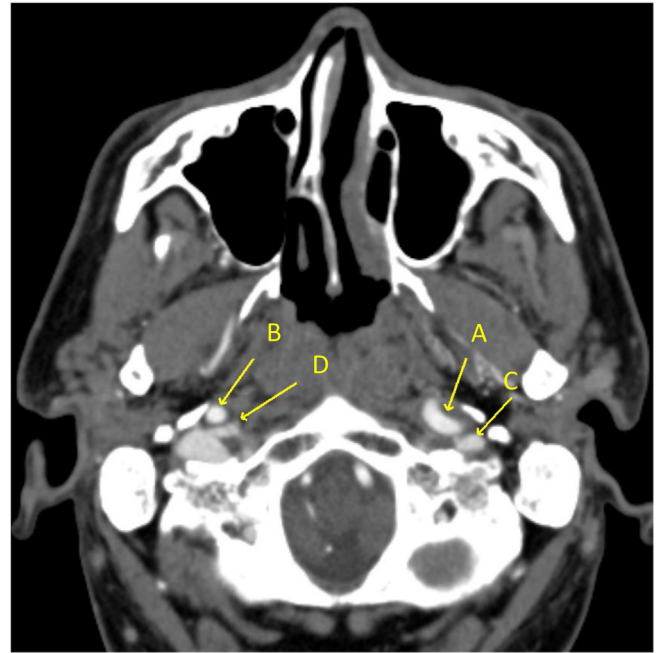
Follow up CTA approximately 3 months after presentation: Source image demonstrates resolving intramural blood products around the left ICA (A) and resolution of mass effect upon the left internal jugular vein (C) and along the path of the hypoglossal nerve. Normal contralateral right ICA (B) and internal jugular vein (D).
